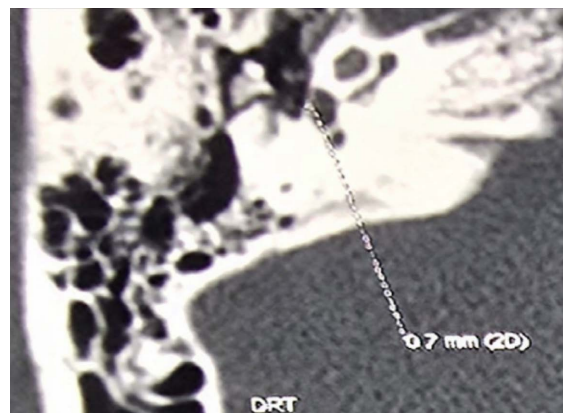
CT scan of the right petrous bone: 0.7 mm squamous plate thickening associated with hypodensity of the antefenestram fustula.
